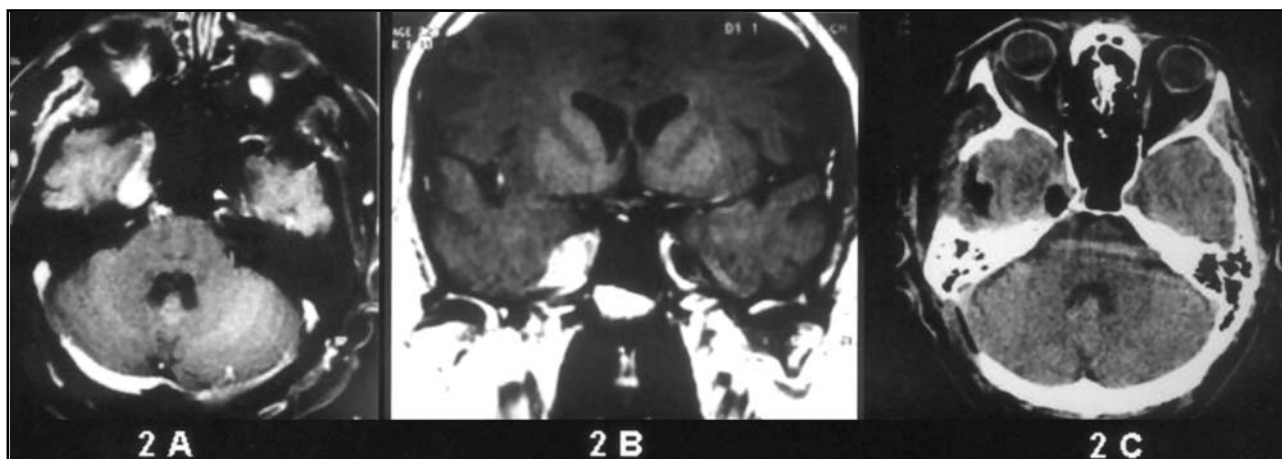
Post contrast T1-weighted axial (2A) and coronal (2B) MRI scans showing expansive lesion at the right Meckels cave and the radical excision after surgery demonstrated by axial CT (2C).
